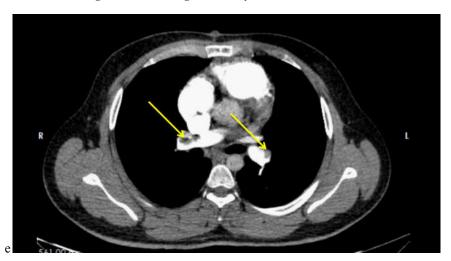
CT Pulmonary Angiogram showing evidence of pulmonary thrombo embolism
